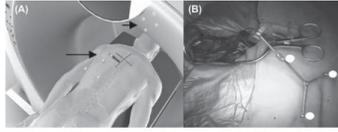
(A) Both the CT marker structures (short arrow) as well as reference star on spine clamp (long arrow) are detected by the optical camera allowing for subsequent autoregistration. (B) Radiolucent spine clamp in situ.
